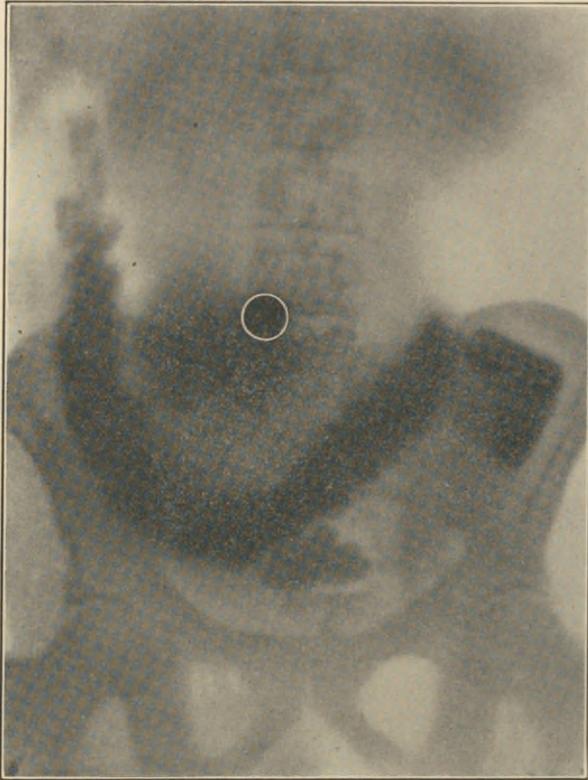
X-RAY PICTURE OF SAME SUBJECT AS SHOWN IN FIG. 138, TAKEN TEN AND ONE HALF HOURS AFTER BISMUTH MEAL.
